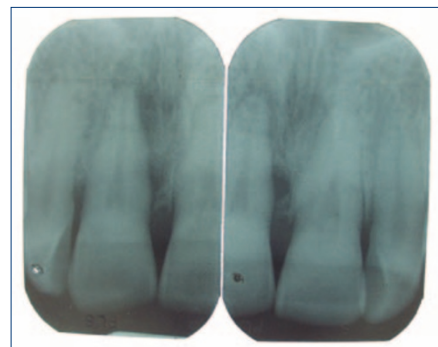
Case 6, radiographs showing lateral periradicular radiolucency
